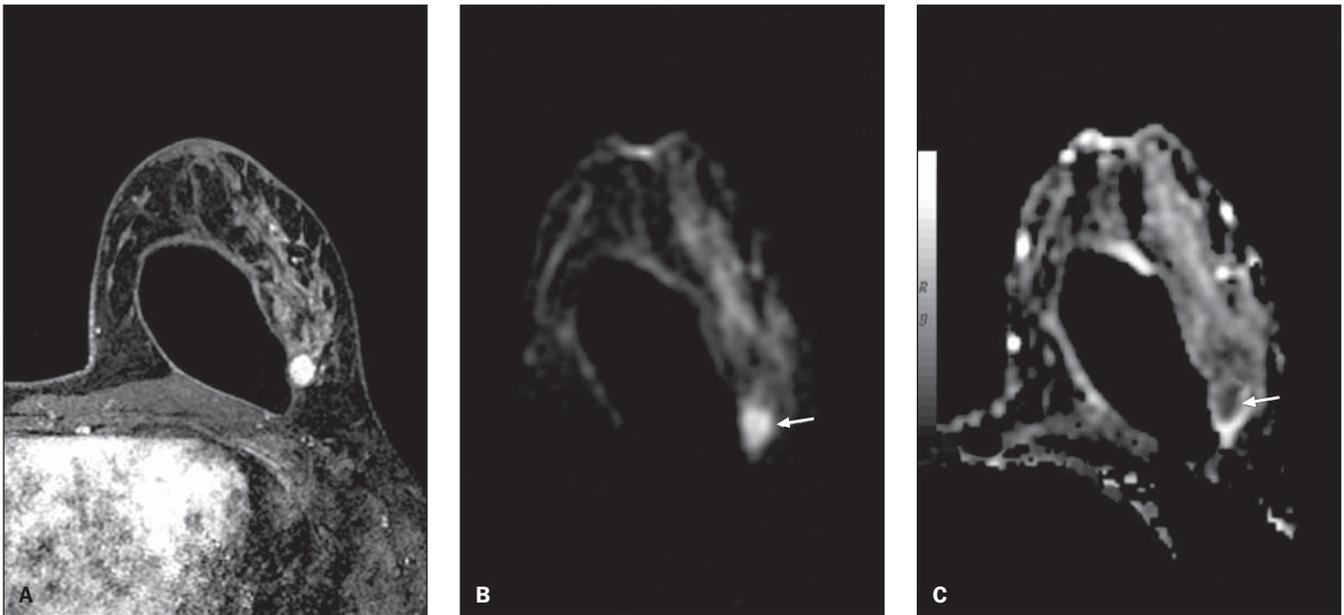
Female, 48-year-old patient presenting infiltrating ductal carcinoma in the left breast. Axial, 3D gradient T1-weighted sequence with fat-suppression at early postcontrast phase (A), diffusion-weighted sequence (b 500 s/mm²) in the axial plane (B), and apparent diffusion coefficient (ADC) black/white map in the axial plane (C) show microlobulated nodule with suspicious contrast-enhancement. Note that the nodule presents high signal intensity on the diffusion (arrow) and signal loss on the ADC map (arrow), suggesting restricted diffusion of water molecules.
